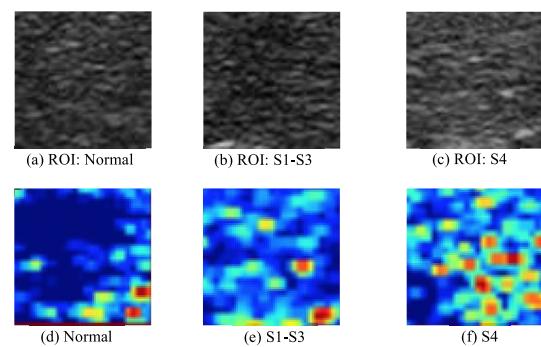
Samples showing original region-of-interest (ROI) ultrasound images and the corresponding heat maps for three different stages of liver fibrosis. (a)-(c) are the ROI ultrasound images, and (d)-(f) are the corresponding heat maps of the ultrasound images. These three images represent three liver statuses: normal (Normal), fibrosis stage 1-3 (S1-S3) and fibrosis stage 4 (S4), respectively.
